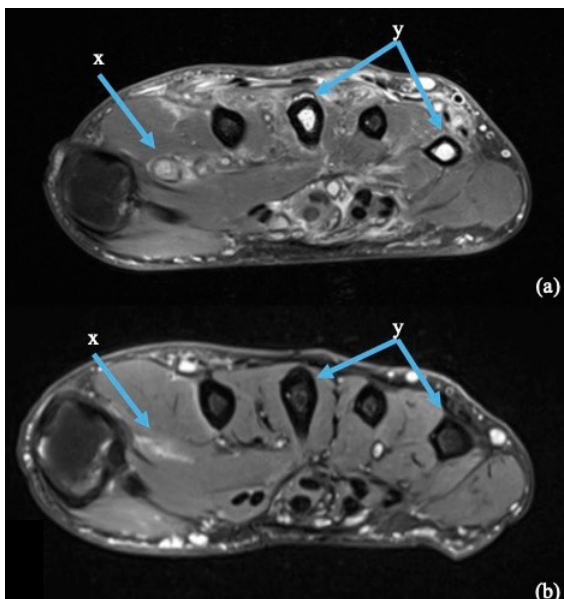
T2-weighted right hand MRI scan: (a) axial view at the time of presentation demonstrating rim-enhancing collection (x) and bony inflammation with marrow oedema (y); (b) axial view following 27 months of antibiotic therapy, demonstrating residual scarring (x) and resolution of bony inflammation (y)
